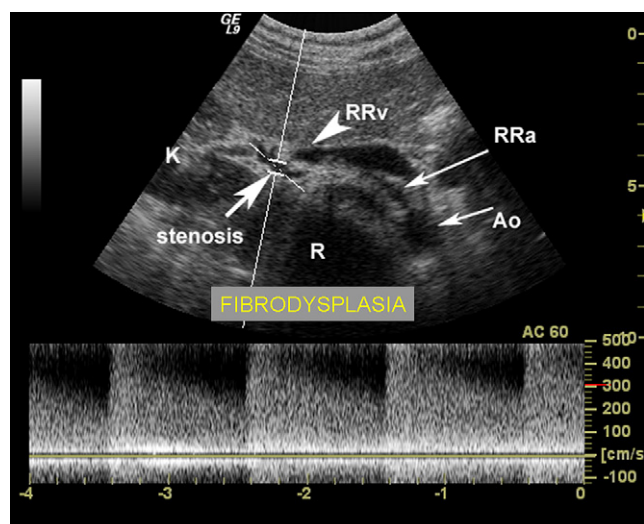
V/t curve in hemodynamically significant stenosis. From a hemodynamic point of view, variations occurring within and immediately downstream from a stenotic segment can alter the morphology of the V/t curve. Within the stenotic segment, there is a significant increase in the peak systolic and diastolic velocities; the flow pattern changes from laminar to vorticose with dispersion of the red-cell velocity in the Doppler spectrum (spectral dispersion and disappearance of the systolic window). The case reported refers to a fibrodysplastic stenosis of the distal segment of the right renal artery.
